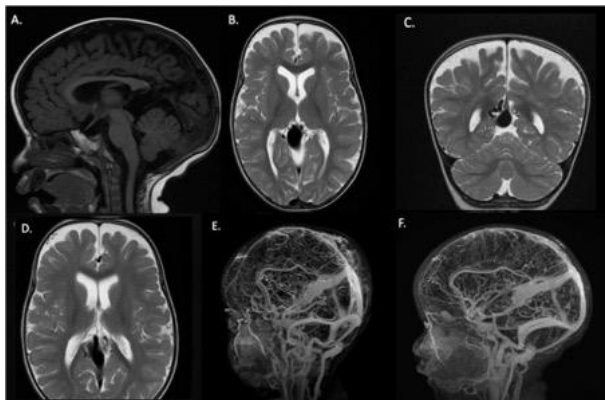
Preoperative brain MRI and contrast-enhanced MR angiography in venous phase. (A) Sagittal T1-weighted image shows signal void within the deep venous system suggestive of Galenic aneurysmal dilation. (B, C, D) Axial and coronal T2-weighted images demonstrate signal voids in the deep venous system consistent with VGAM. (E, F) 3D reconstructions of contrast-enhanced venous phase MR angiography showing aneurysmal dilation consistent with VGAM.
